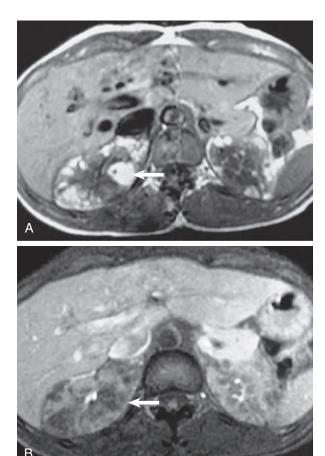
Tuberous sclerosis on MRI. Multiple renal angiomyolipomas are seen. (A) T1-weighted MR image. The tumors are high in signal on T1 because of their fat; *arrow* shows the largest tumor. (B) T1-weighted MR image with fat suppression. The fat within the tumors is now low in signal *(arrow)*.
